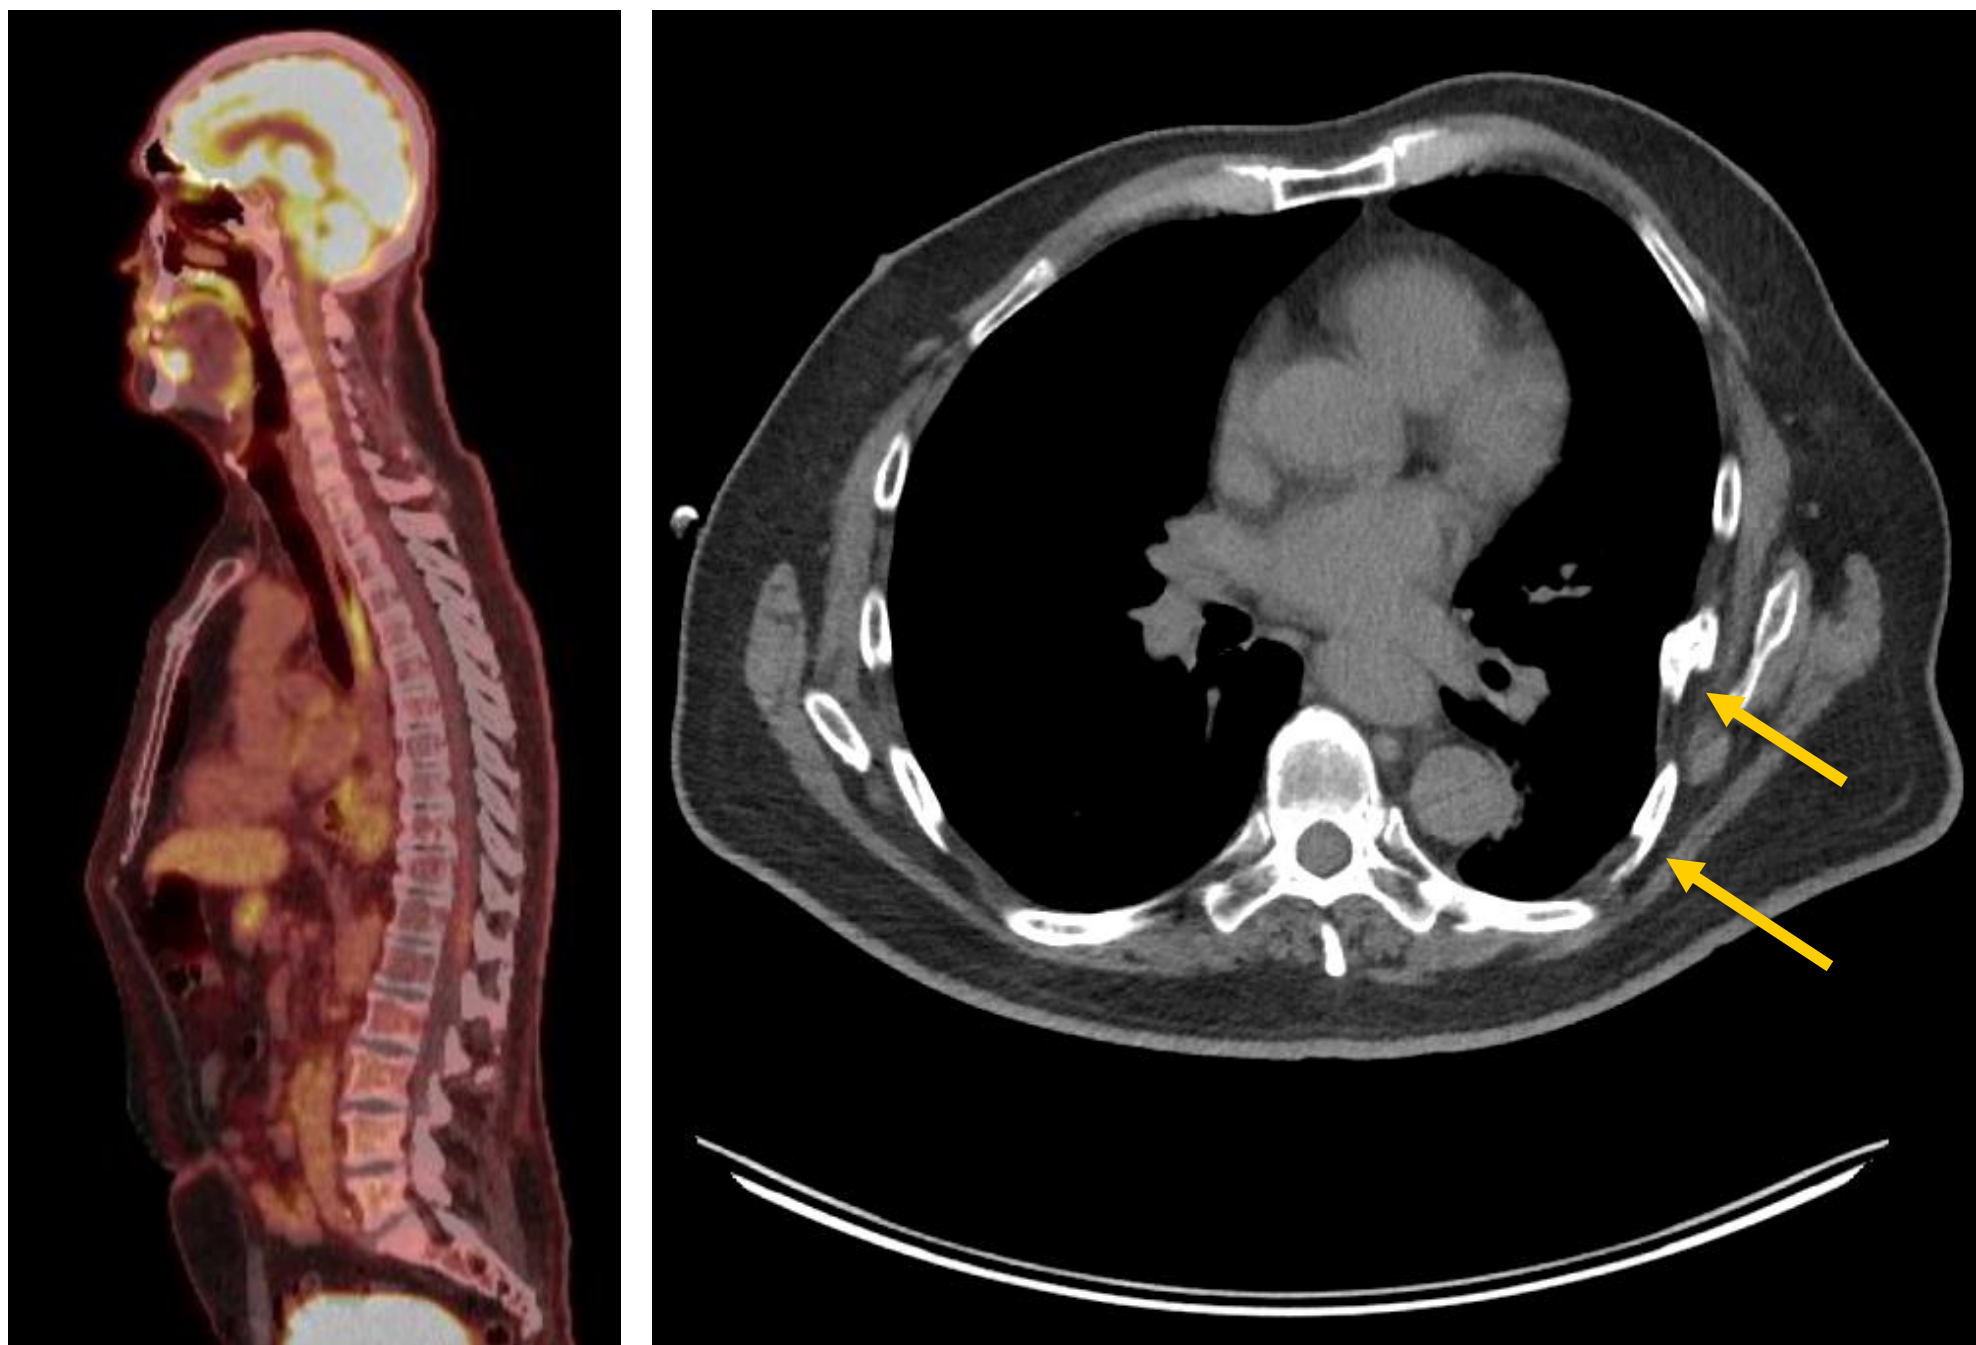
PET CT demonstrating evidence of chest wall deformity (yellow arrows) and sclerosis from prior injury. No other preoperative imaging studies performed.
